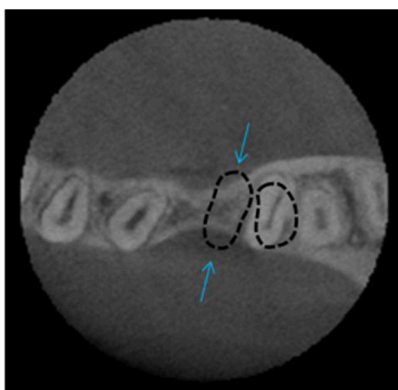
CBCT before alveolar decortications, the mesial root of mandibular second molar following to the treatment plan was moved out off alveolar bone housing
